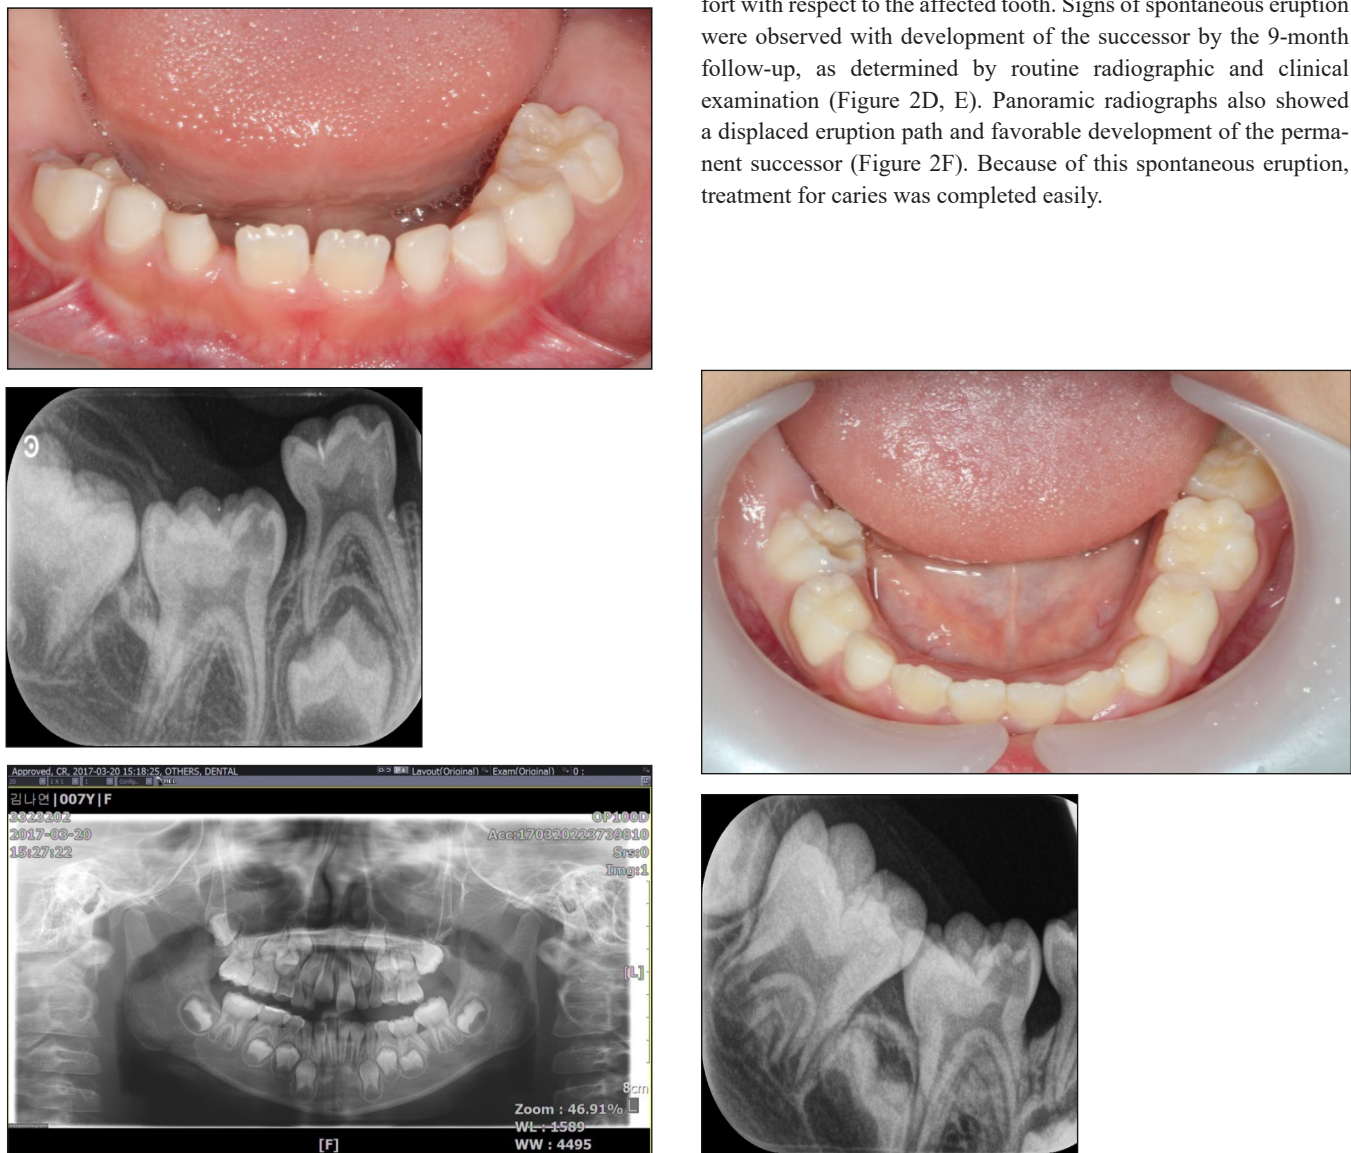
Case 2. (A) Initial intraoral view showing the non-erupted state of the right mandibular primary molar. (B) Periapical view showing dental caries in the right mandibular second primary molar. (C) Panoramic view showing the mandibular right premolar positioned inferiorly and distally to coronal portions of the infraoccluded primary molar. (D) Nine months later, the affected primary molar re-erupted without intervention. (E) Periapical view showing that the right mandibular second primary molar reached occlusal level. (F) Panoramic view showing re-eruption of the affected molar and favorable development of the permanent successor.
